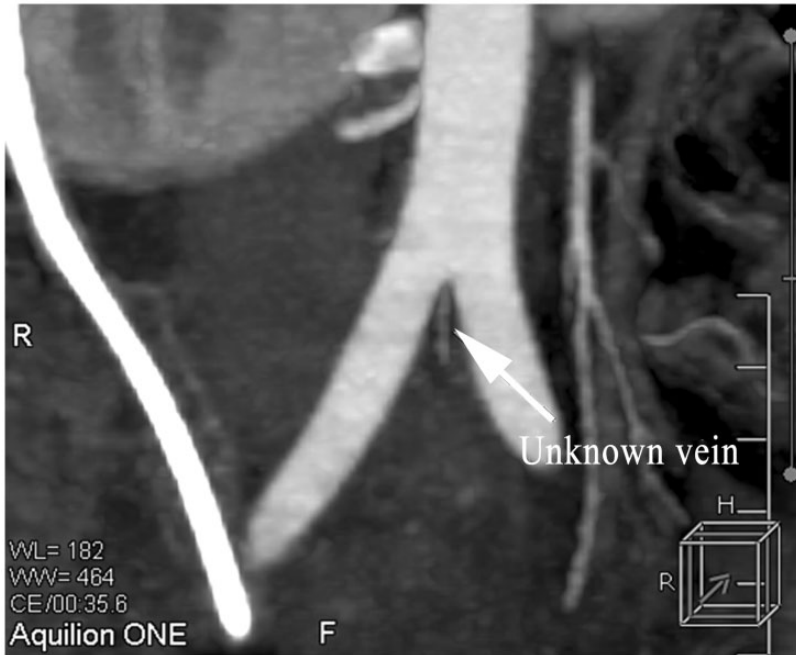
Postoperative multi-slice computed tomography angiography image of a 42-year-old woman who underwent elective surgery for stage IIA1 cervical squamous cell carcinoma confirming that the ureter and renal vessels merged into the kidney separately.
